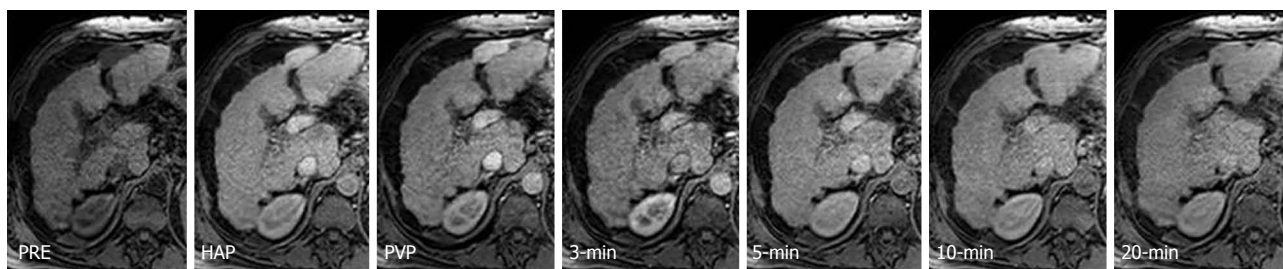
Gadoteric acid contrast-enhanced magnetic resonance images obtained in a 57-year-old man with Child-Pugh C hepatitis C virus-related cirrhosis. Contrast-enhanced magnetic resonance images show slight decrease of liver enhancement after the portal venous phase. On hepatic arterial and portal venous phases, the intrahepatic vessels show intense and homogeneous enhancement, which persists on 3 min, 5 min, and 10 min phase. On 20 min phase, the intrahepatic vessels show isointensity to the liver. Prolonged retention of the contrast in intrahepatic vessels indicates impaired hepatic function and an inadequate hepatobiliary phase. Twenty minutes phase corresponds in this case to the transitional phase observed in normal liver patient due to prolonged retention of gadoteric acid in intrahepatic vessels. Also, note that the kidney shows isointensity to the liver on 10 min and 20 min phases, indicating a compensatory increase of renal elimination of gadoteric acid and an inadequate hepatobiliary phase. PRE: Precontrast; HAP: Late hepatic arterial phase; PVP: Portal venous phase.
